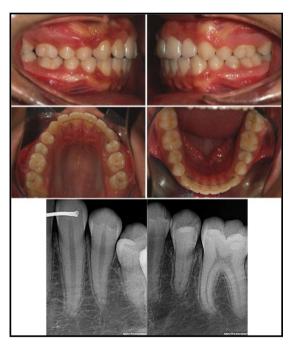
The initial records of the patient. (A,B,C,D) The intraoral photographs of the patient. (E) The initial panoramic radiograph. (F) Congenital absence of tooth 35 can be seen from this initial periapical radiogram. The place of the deciduous left second molar is used for auto-transplantation of the tooth 24. Written permission for use of photos was obtained from his parents.
